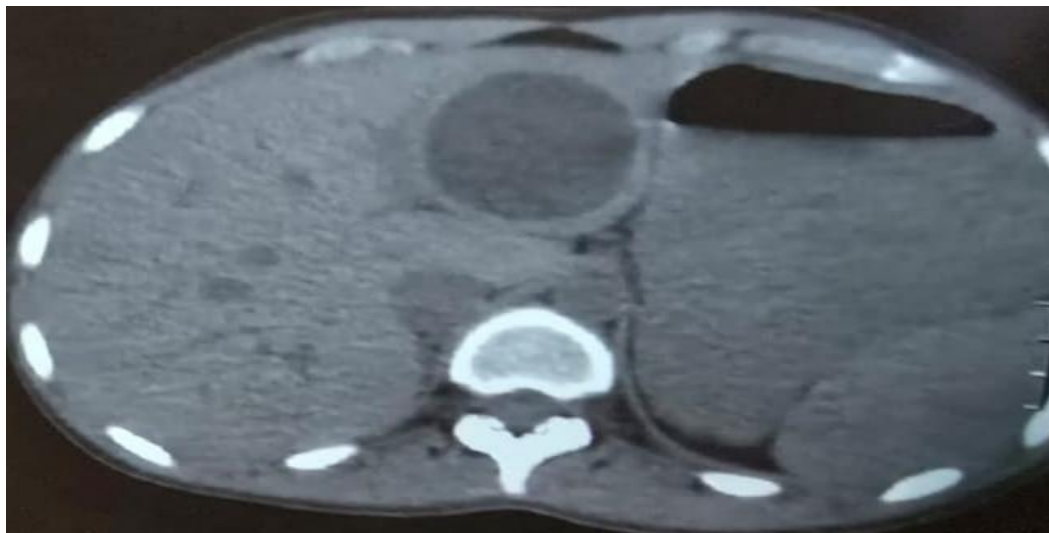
Computed tomography scan showing Hydatid cyst in left lobe of liver
